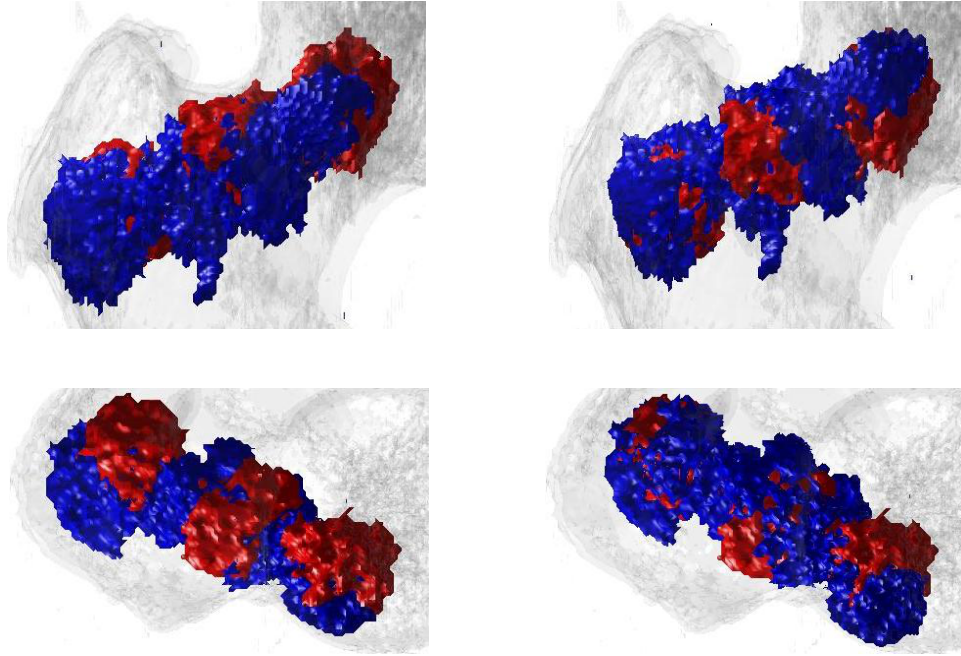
Comparison of cement isosurfaces before (left) and after (right) ICP registration. Red indicates the planned cement distribution while blue indicates the cement cloud obtained from post-operative CT scan.
